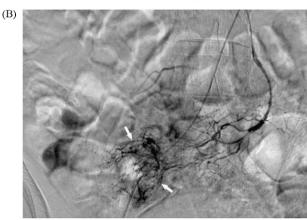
A 74-year woman presented with symptoms of AGIB. The endoscopy was performed, but failed to detect the active bleeders. (A) Arterial phase CT scan on coronal plane showed a well-defined enhancing soft-tissue mass (M) over the distal ileum. Contrast was extravasated (black arrows) into the intestinal lumen. The engorged mesenteric artery (white arrow) was also evident. (B) Angiography showed a hypervascular tumor with contrast extravasation (white arrows) that corresponding to the MDCT findings. Gastrointestinal stromal tumor of the small intestine with active bleeding was confirmed after surgery.
